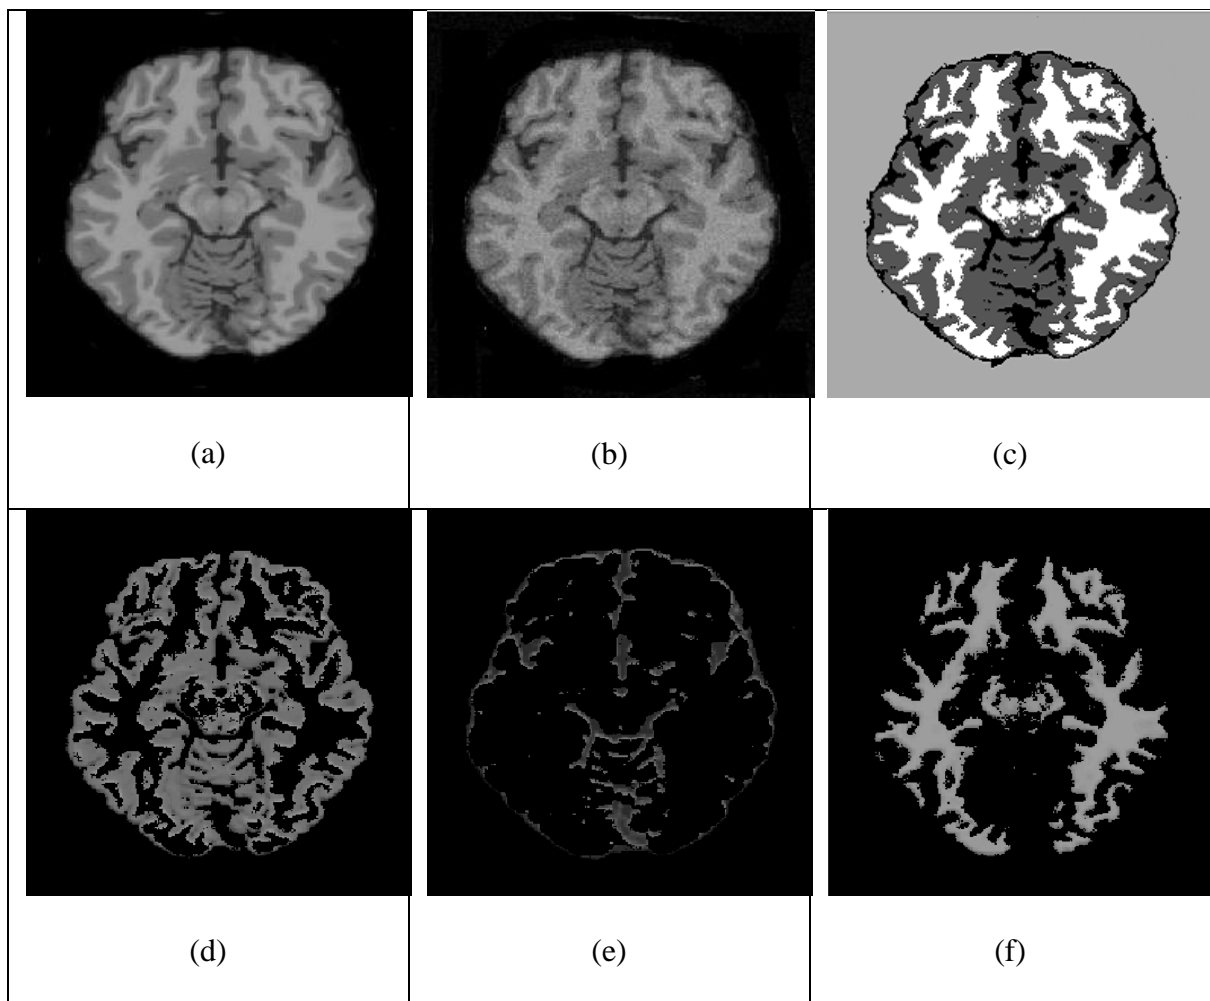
(a) Normal Brain(T1-weighted slice 60), (b) Normal brain (noise 3%), (c) Segmented result using FUZZY GSA, (d) Gray matter, (e) CSF, (f) White matter
